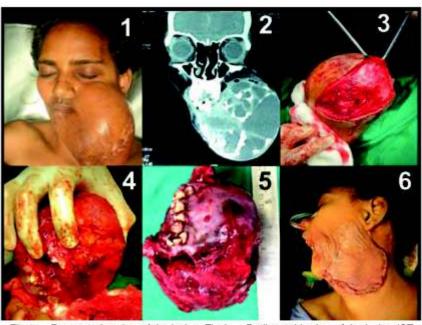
Pre-operative view of the lesion; Fig 2 — Radiographic view of the lesion (CT-SCAN); Fig 3 — Cervical incision given for lesion exposure; Fig 4 — Lesion exposure and removal in toto; Fig 5 — Lesion removed completely; Fig 6 — Sutures taken after removal done
